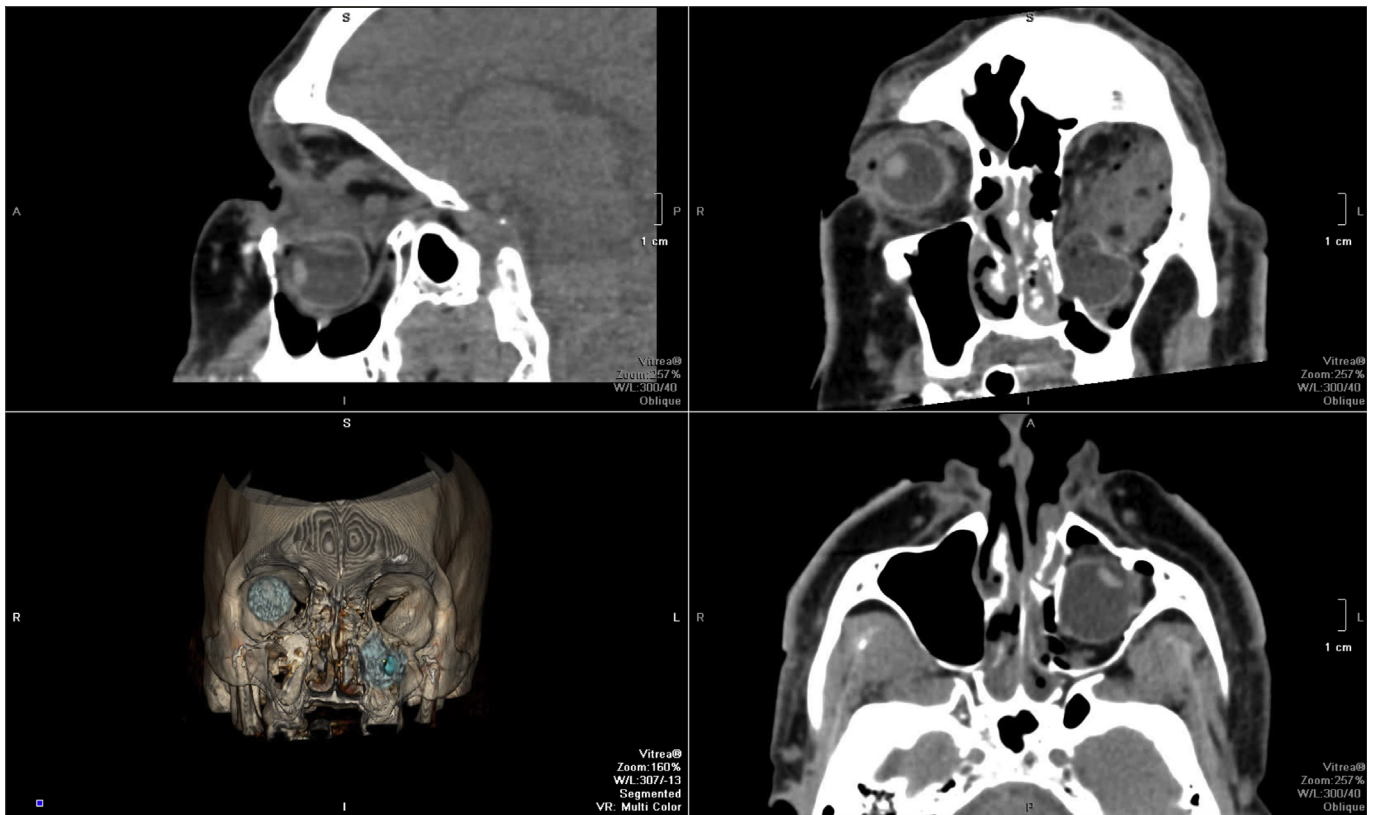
Clockwise from top left. Sagittal, coronal, and axial views of non-contrast computed tomography (CT) and 3-dimensional (3D) reconstruction showing total displacement of the left globe in to the left maxillary sinus.
